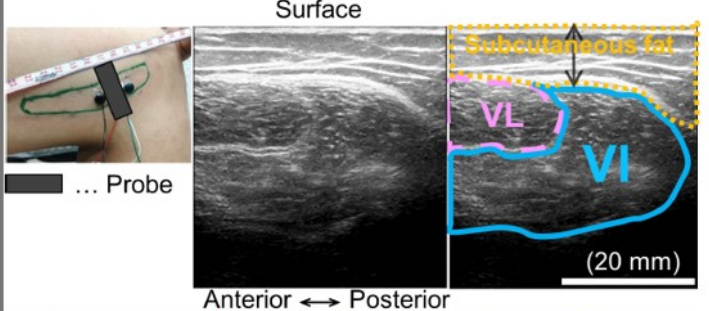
The ultrasound image of place of attachment electrodes of VI for the woman.
